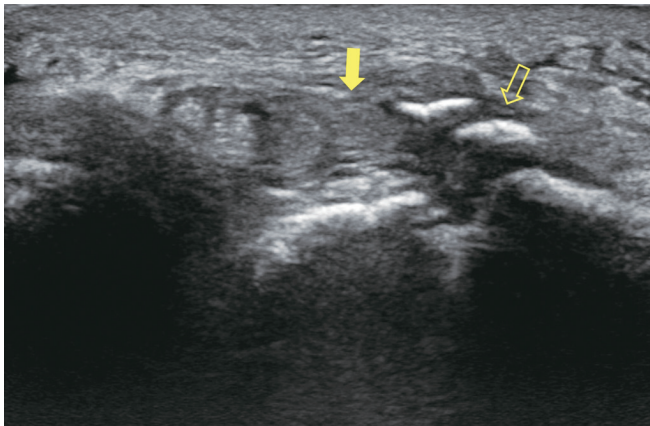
Axial image of ultrasonography showed complete disruptions of the extensor pollicis longus, (solid arrow) and fracture gap of Lister's tubercle (vacant arrow).
